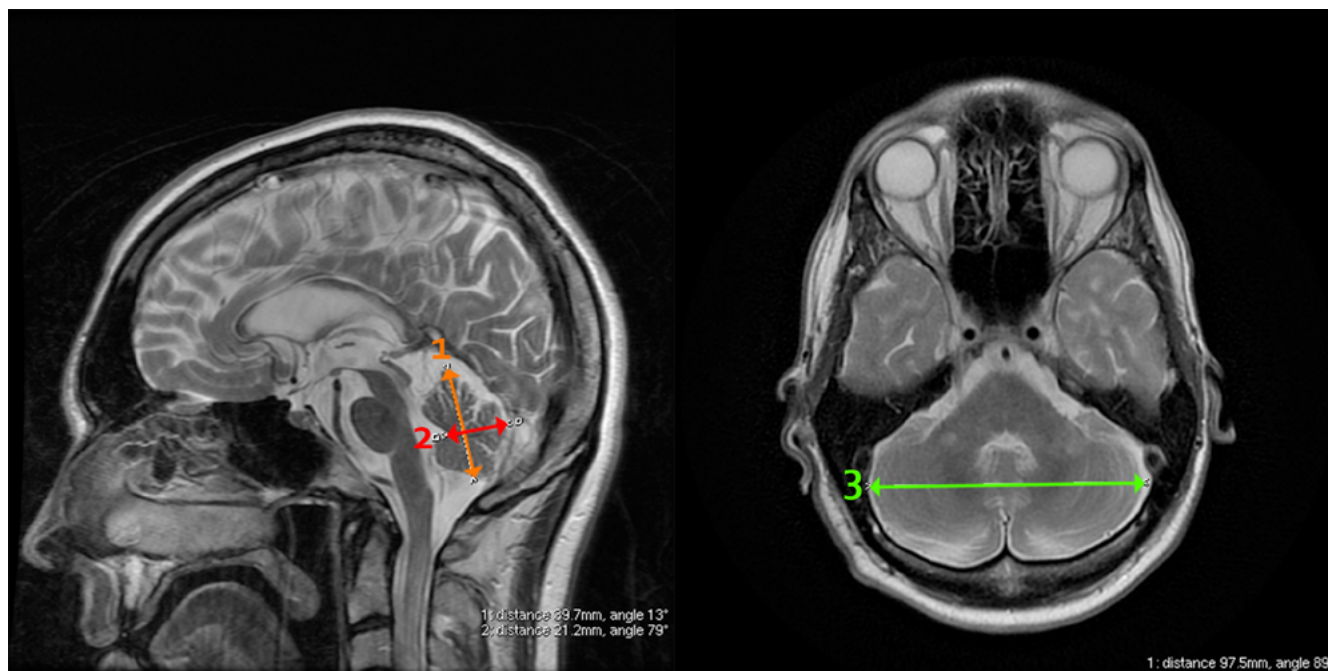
Cerebellum linear measurements on T2-weighted sagittal and axial plains cerebellum height (1 – orange arrow), cerebellum width (2 – red arrow) and transverse cerebellar diameter (3 – green arrow).
